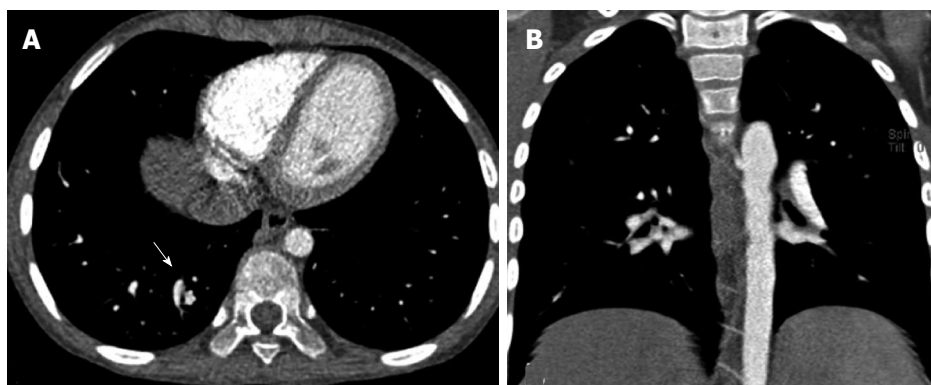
Pulmonary arteriovenous malformation. Axial (A) and coronal (B) computed tomography images showing abnormal communication between branches of the pulmonary artery and vein in right lower lobe (arrows).
